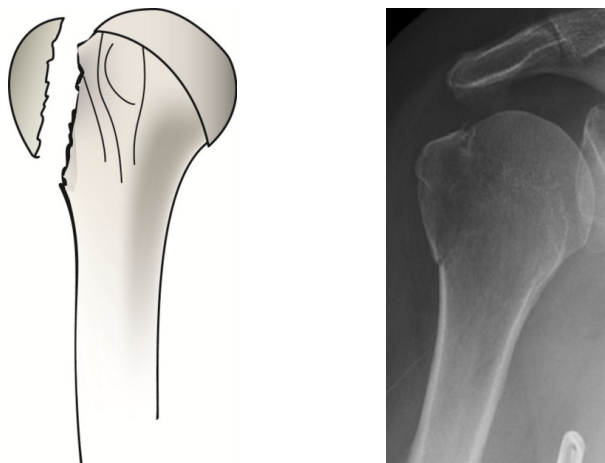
/Radiograph 2: An artist's rendition and anteroposterior radiograph of the typical Split-type fracture. The fragment is large and the fracture line is vertical, extending to or distal to the level of the surgical humeral neck.
